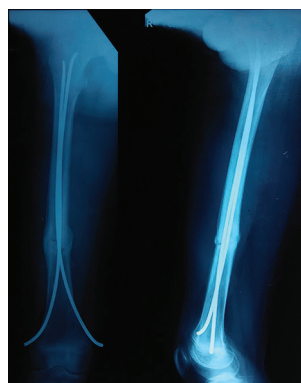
X-ray at 12 weeks
